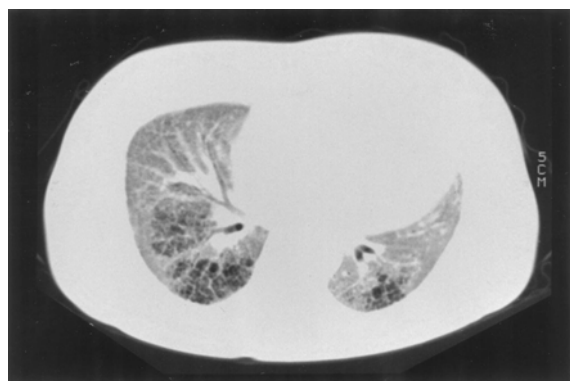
Preoperative chest CT scan demonstrating honeycomb pattern in the lung field.
